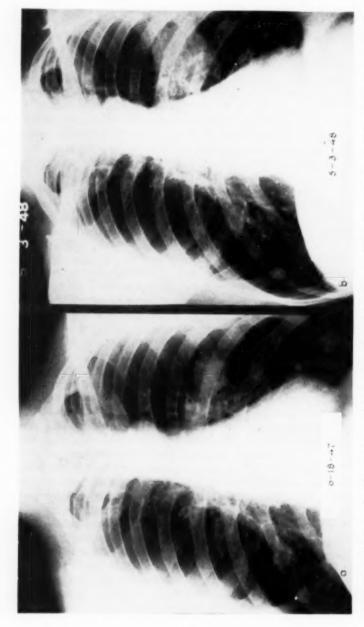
(Case 1): Carcinoma lung arising as peripheral nodule.—(A) Nodule in left lung, poorly defined, peripheral position, found six months earlier during chest survey.—(B) Extension of mass peripherally and centrally. Symptoms now present, 15 months after original x-ray finding. Pneumonectomy shows squamous cell carcinoma lingular segment left upper lobe.
